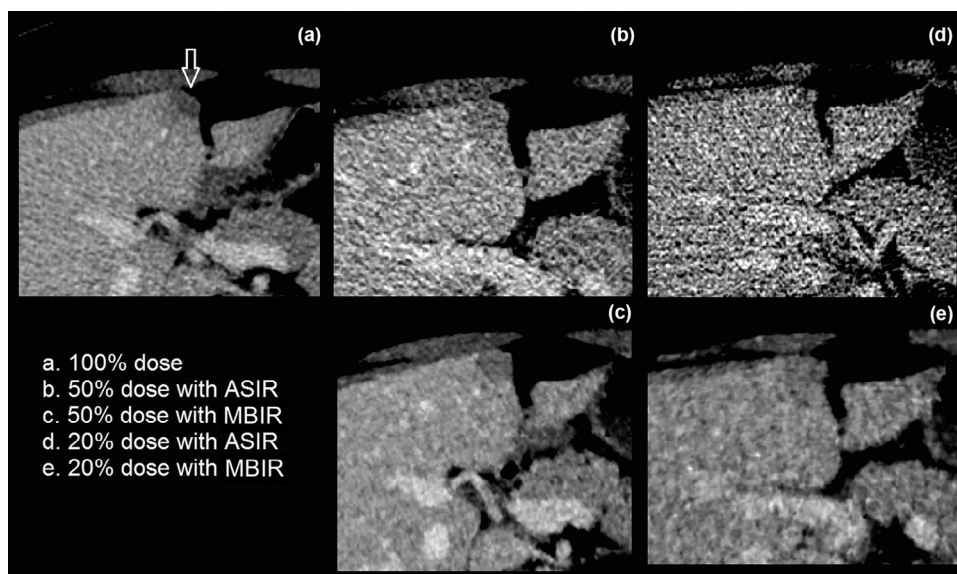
Side-by-side comparison of a subtle low-contrast liver lesion for the two iterative reconstruction algorithms and dose levels. A focal fatty area located within the hepatic parenchyma was detected on the 100% dose CT image (a, arrow). Note that it is not confidently seen on the 50% dose MBIR image (c), and is almost undetectable on both ASIR images (b,d) and on the 20% MBIR image (e). ASIR, adaptive statistical iterative reconstruction; MBIR, model-based iterative reconstruction.
